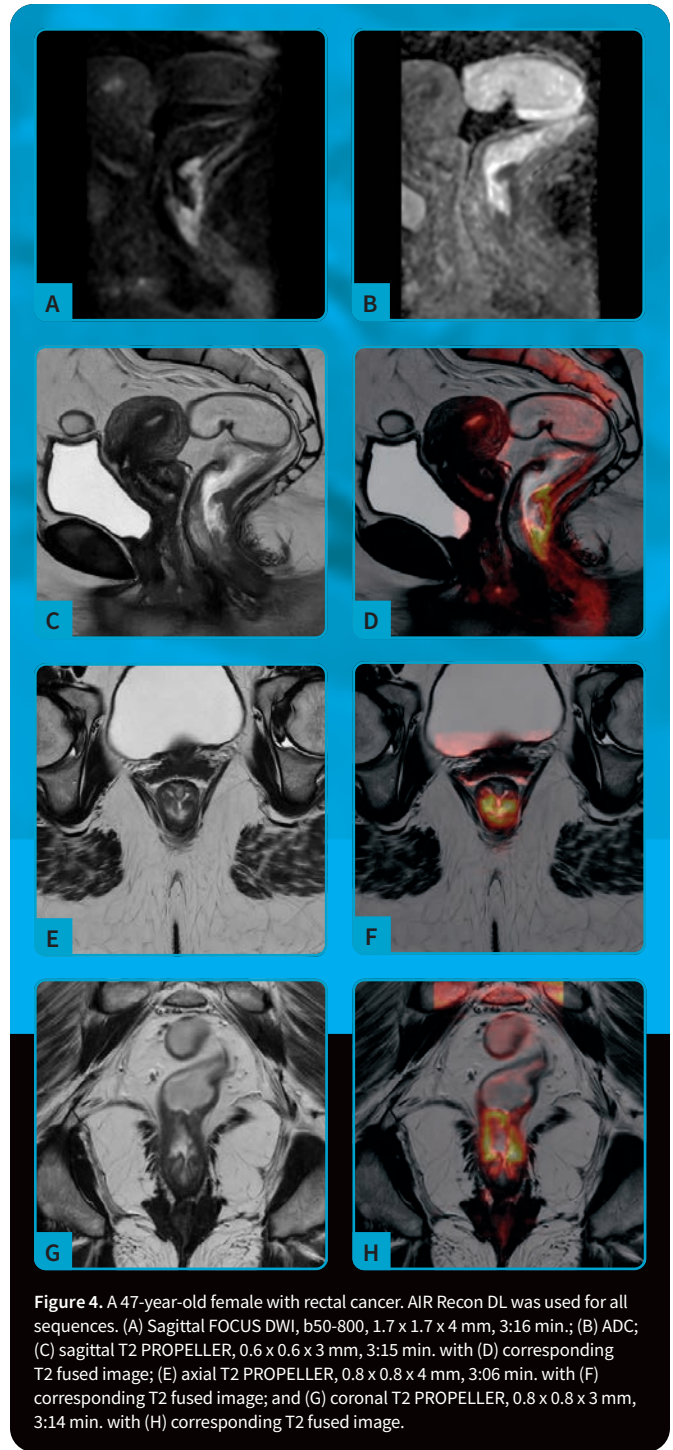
A 47-year-old female with rectal cancer. AIR Recon DL was used for all sequences. (A) Sagittal FOCUS DWI, b50-800, 1.7 x 1.7 x 4 mm, 3:16 min.; (B) ADC; (C) sagittal T2 PROPELLER, 0.6 x 0.6 x 3 mm, 3:15 min. with (D) corresponding T2 fused image; (E) axial T2 PROPELLER, 0.8 x 0.8 x 4 mm, 3:06 min. with (F) corresponding T2 fused image; and (G) coronal T2 PROPELLER, 0.8 x 0.8 x 3 mm, 3:14 min. with (H) corresponding T2 fused image.
